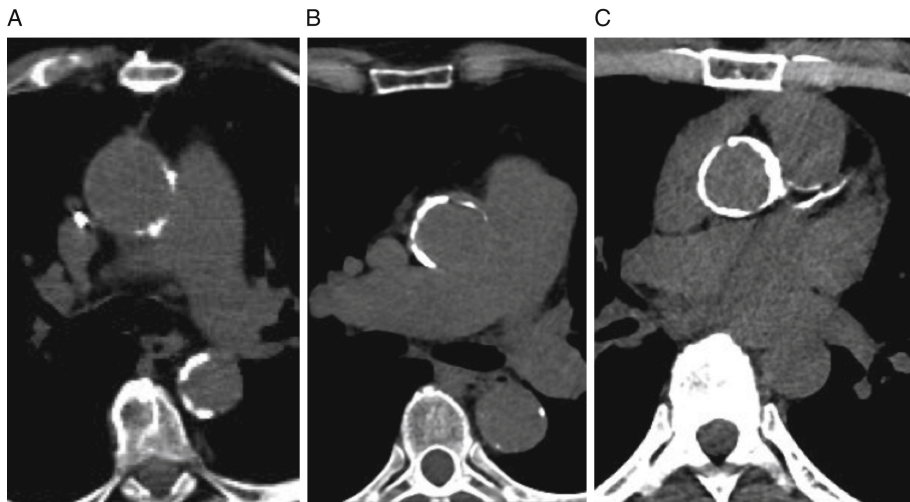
Examples of thoracic aortic calcification. A patient with mild (A), moderate (B) and circumferential (C) calcification of the thoracic aorta as detected by a calcium scoring CT scan (Desai et al. 2018).
